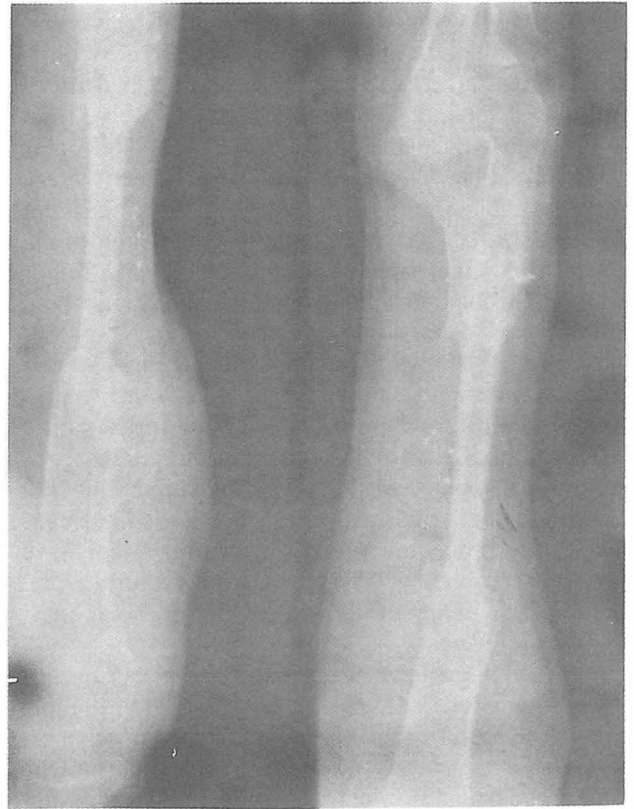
X-ray of the arm of the same patient (Fig 3) four months postoperatively.
